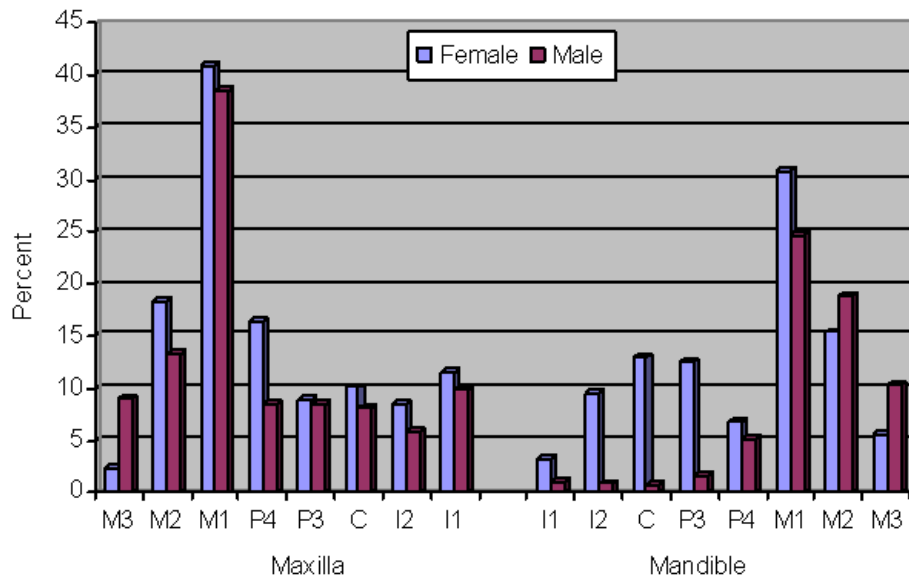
Frequencies of Periapical Abscesses in Female and Male Maxillary and Mandibular Dentitions for CA-CCO-18/548.
